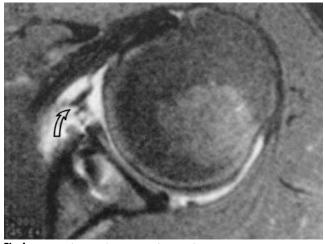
Proton density fast spin echo axial magnetic resonance imaging, demonstrating an apparent disruption of a portion of the glenohumeral ligament (curved arrow).
